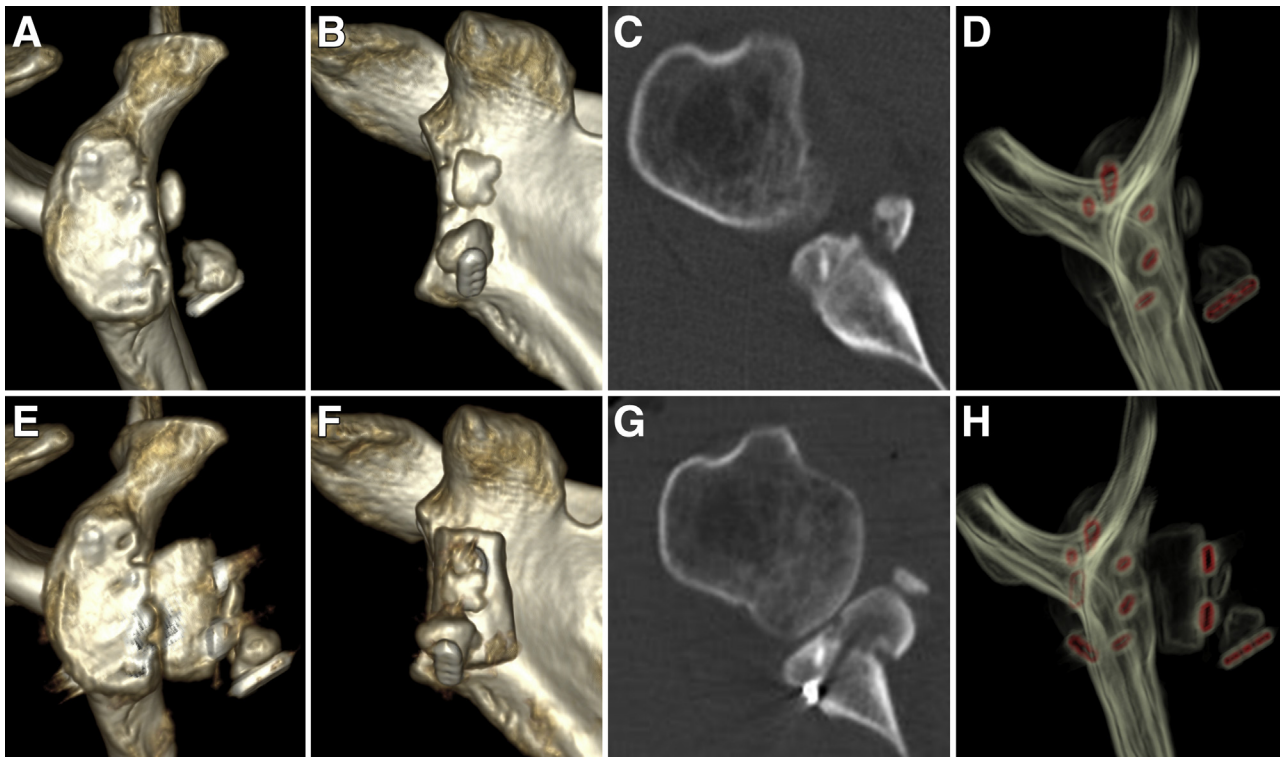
CT scan preoperation and postoperation. (Right shoulder) Pre-operation: en-face view of three-dimensional (3D) computed tomography (CT) (A), anterior view of 3D CT (B), axial view of 2D CT (C), and hardware-enhanced CT view (D). Post-operation: En-face view of 3D CT (E), anterior view of 3D CT (F), axial view of 2D CT (G), and hardware enhanced CT view (H). (A case of failed arthroscopic Latarjet with suture button fixation, revision by arthroscopic “double-inlay” Eden-Hybinette with modified suture button fixation; D and H: red parts show the metal implants).
